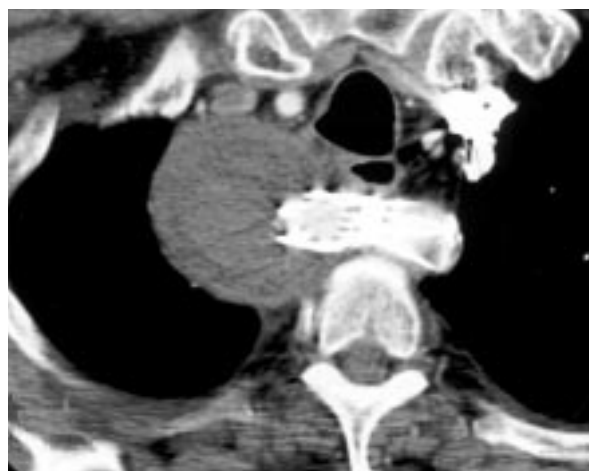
Computed tomography scan shows flow in the stent graft lumen with thrombosis of the aneurysm.
